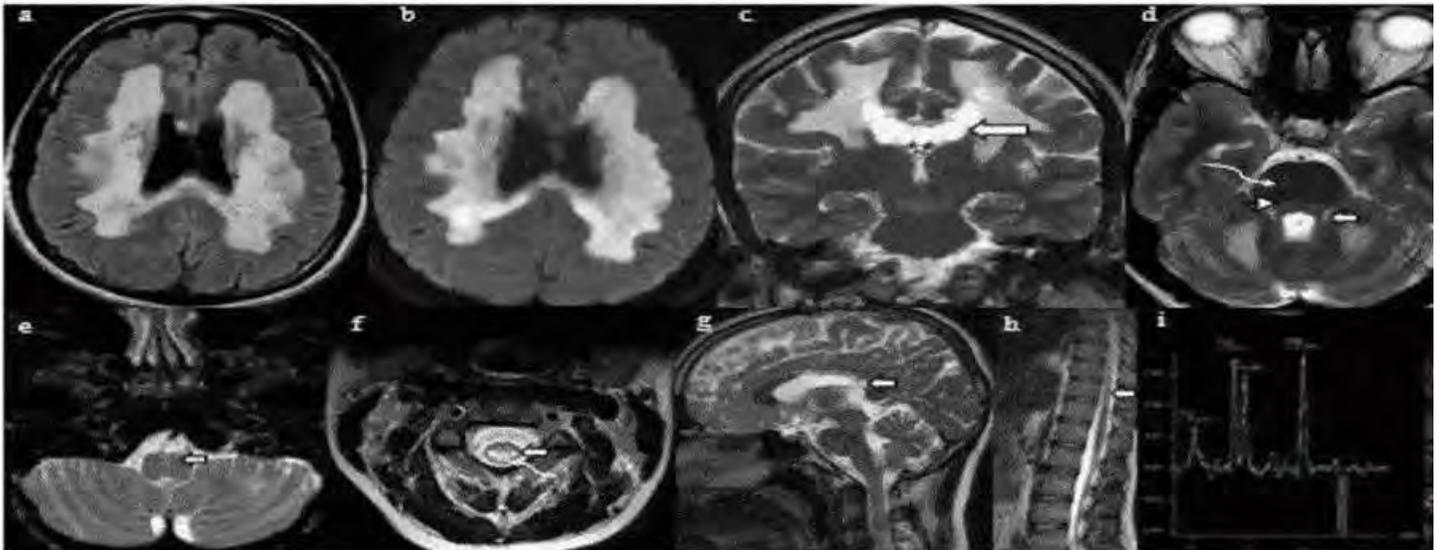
MRI in LBSL (DARS mutation): Images depict noncavitary leukoencephalopathy, corticospinal tract involvement (squiggly arrows in 'd'), lateral spinothalamic and posterior column tract involvement (arrows in 'f'), prominent lactate in MRS.
